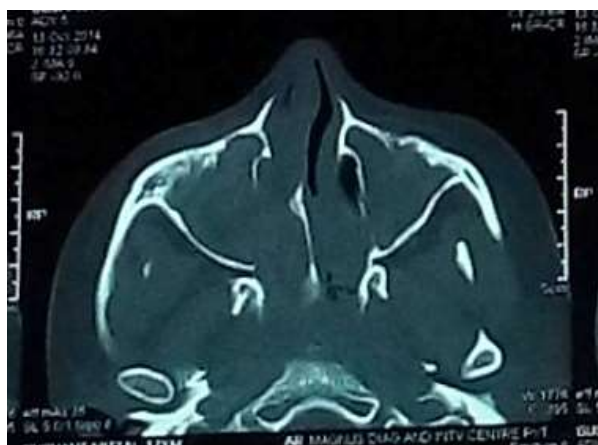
CT nose and PNS (axial view) with Lund-Mackay score of >8 on each side.
